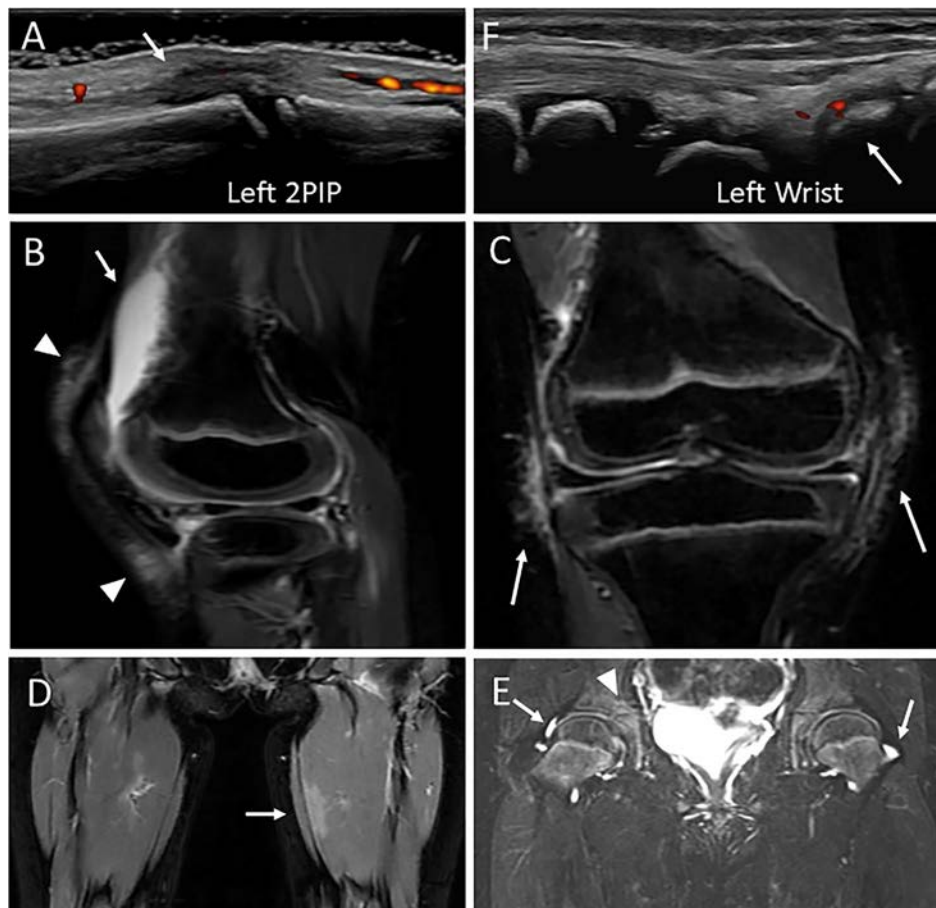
Musculoskeletal ultrasound and MRI findings in our case. (A) Musculoskeletal ultrasound showing hypoechoic area with power doppler signals around the extensor tendon of the left second finger (arrow). (B, C) Lower limb STIR MRI showing suprapatellar joint effusion, mild synovial proliferation (B, arrow), patellar tendon insertions (B, arrow heads), and hyperintensity lesions around the medial and lateral collateral ligaments (C). (D) Thigh STIR MRI showing hyperintense lesions in the adductor muscle group (arrow). (E) Coronal STIR MRI of both hips demonstrating joint effusion and bone marrow edema in the femoral heads (arrow) and acetabula (arrow head). (F) Musculoskeletal ultrasound showing hypoechoic area with power Doppler signals in the left wrist joint (arrow).
